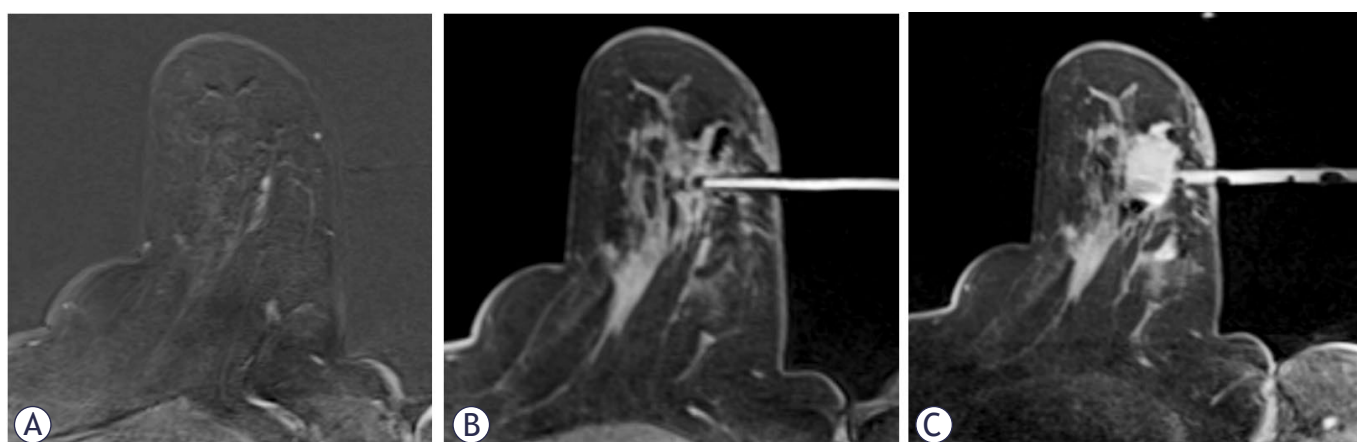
MRI-guided breast biopsy with hematoma as a sequela. (A) Target lesion in the lower outer quadrant. (B) Biopsy needle in target position. (C) After vacuum-assisted biopsy, a hematoma has formed. Within it, a recognizable susceptibility artifact is due to the marker.
